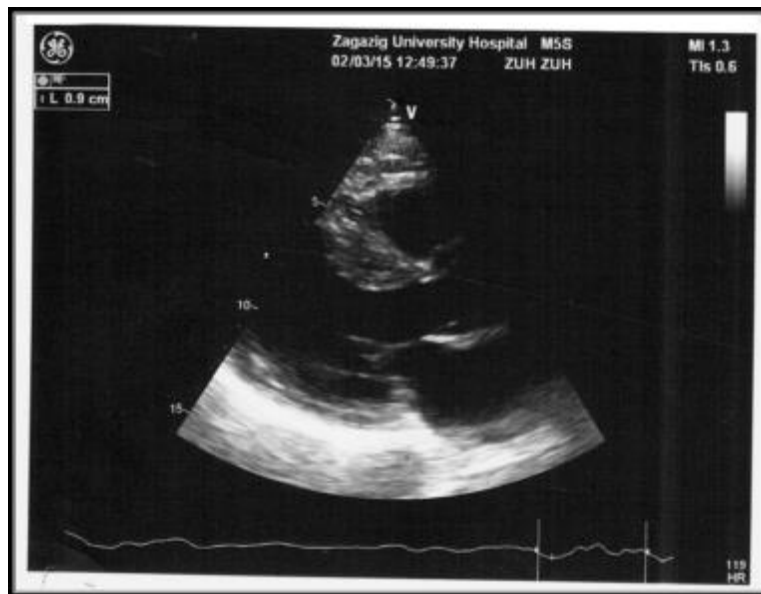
Parasternal long axis view showing EAT thickness 9 mm.
